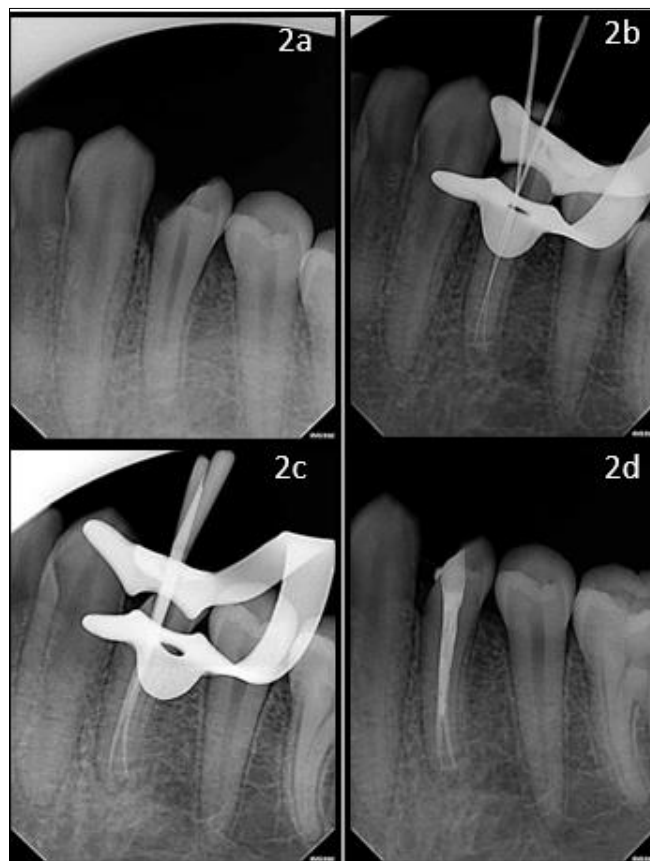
a- Pre-operative radiograph showing fracture cusp
